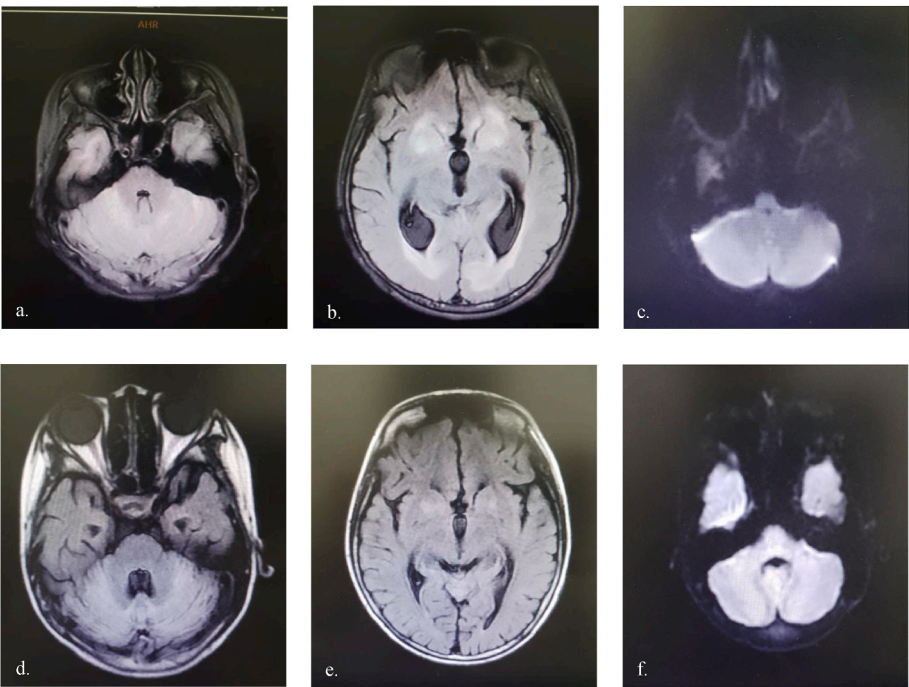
At the time of admission, the child’s cranial MRI showed symmetric high signal in the cerebellum (a.) and bilateral basal ganglia regions (b.) on the T2 Flair sequence, and symmetric diffusion restriction in the bilateral cerebellum on the DWI sequence (c.); after the treatment, the child’s cranial MRI showed reduced high signal in the cerebellum (d.) and bilateral basal ganglia regions (e.) on T2 Flair sequences, and bilateral cerebellar symmetric diffusion restriction disappeared on DWI sequences (f.).
